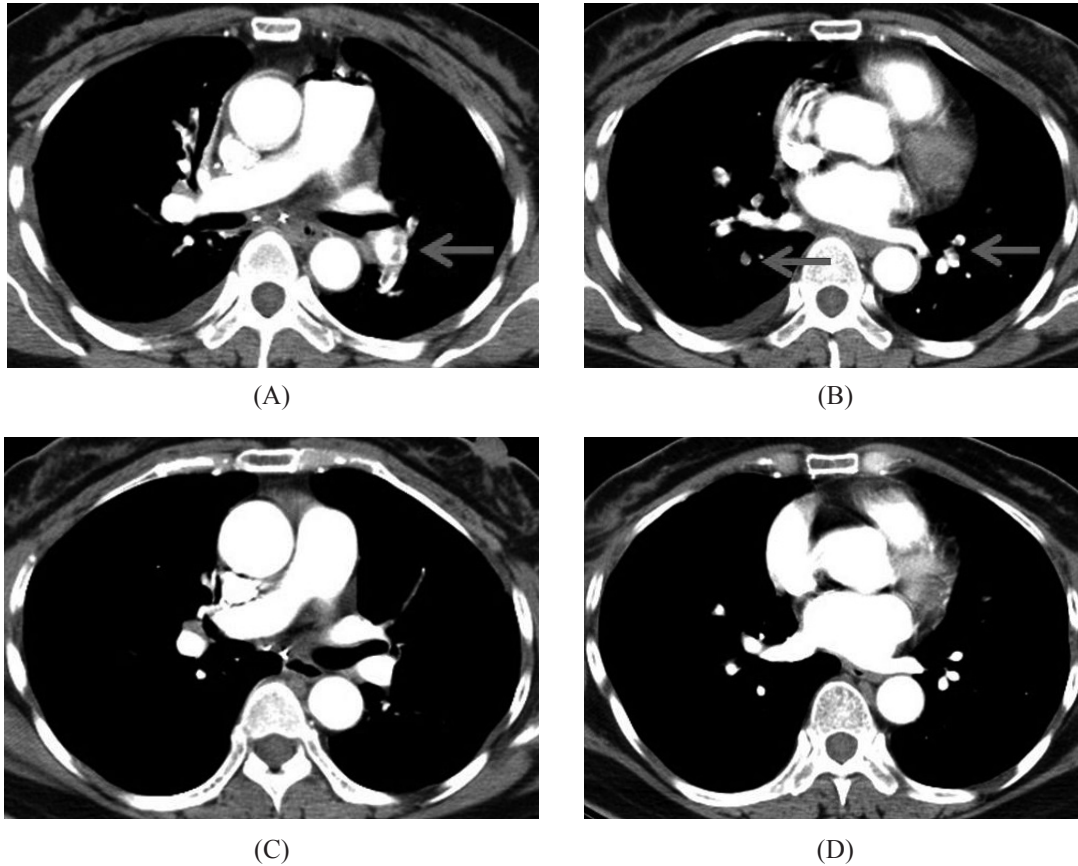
HRCT of the patient with pulmonary embolism after lung resection. A and B: Chest CT, contrast, at the time of pulmonary embolism. Filling defect noted in the distal left main pulmonary arteries and bilateral peripheral pulmonary arteries (arrow site); C and D: Chest CT, contrast, at follow-up 6 months later. Filling defect could no longer be seen in the pulmonary arteries.
